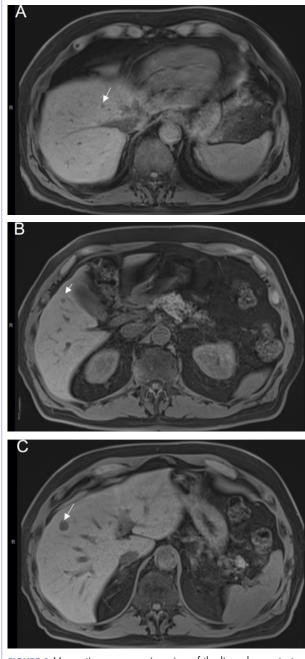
Magnetic resonance imaging of the liver demonstrating metastatic disease (arrows, A and B), with a 1.2×1.3 -cm mass in the hepatic segment 4a/8 (C).
